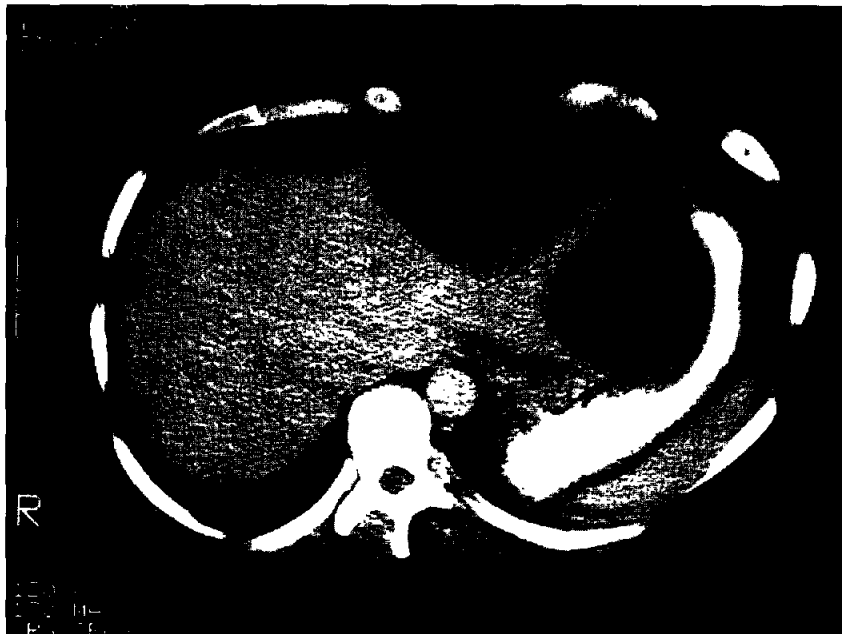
CT scan demonstrating a bile collection or "biloma" following isolated hepatic duct injury.
